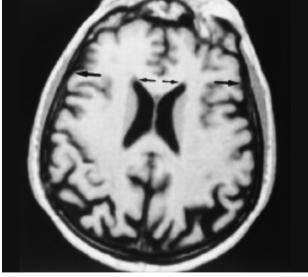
Axial MR image showing the width between the frontal horns of the lateral ventricles (smaller arrows) and the cranial width (larger arrows) – Bifrontal Index.
